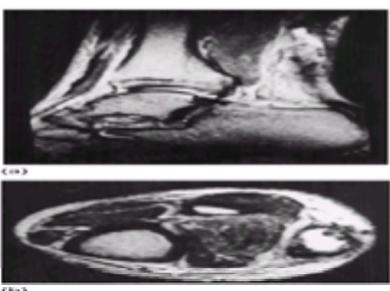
MRI of the tendo-Achillis showing a degenerate and ruptured tendon. The capsule around the tendon seems intact but the space between the two frayed ends is filled with fluid.
